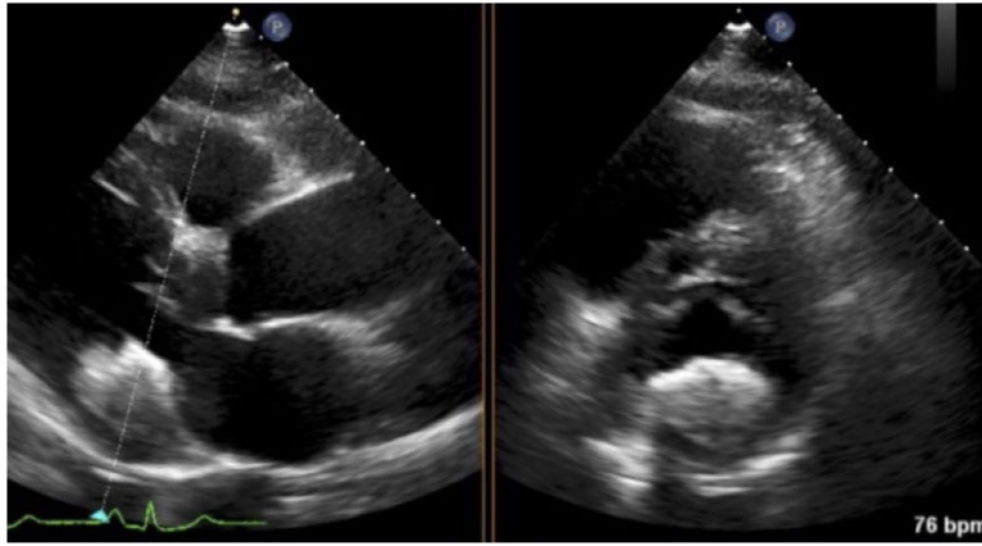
Initial echocardiography. Initial transthoracic echocardiography at first presentation. The parasternal long axis is shown on the left, whereas the basal short axis is shown on the right. Transthoracic echocardiogram reveals an echo-lucent, sclerotic structure of 28 mm × 24 mm × 21 mm at the posterior mitral annulus with a posterior echo shadow. There were no signs of mitral valve regurgitation or stenosis and normal biventricular function.
